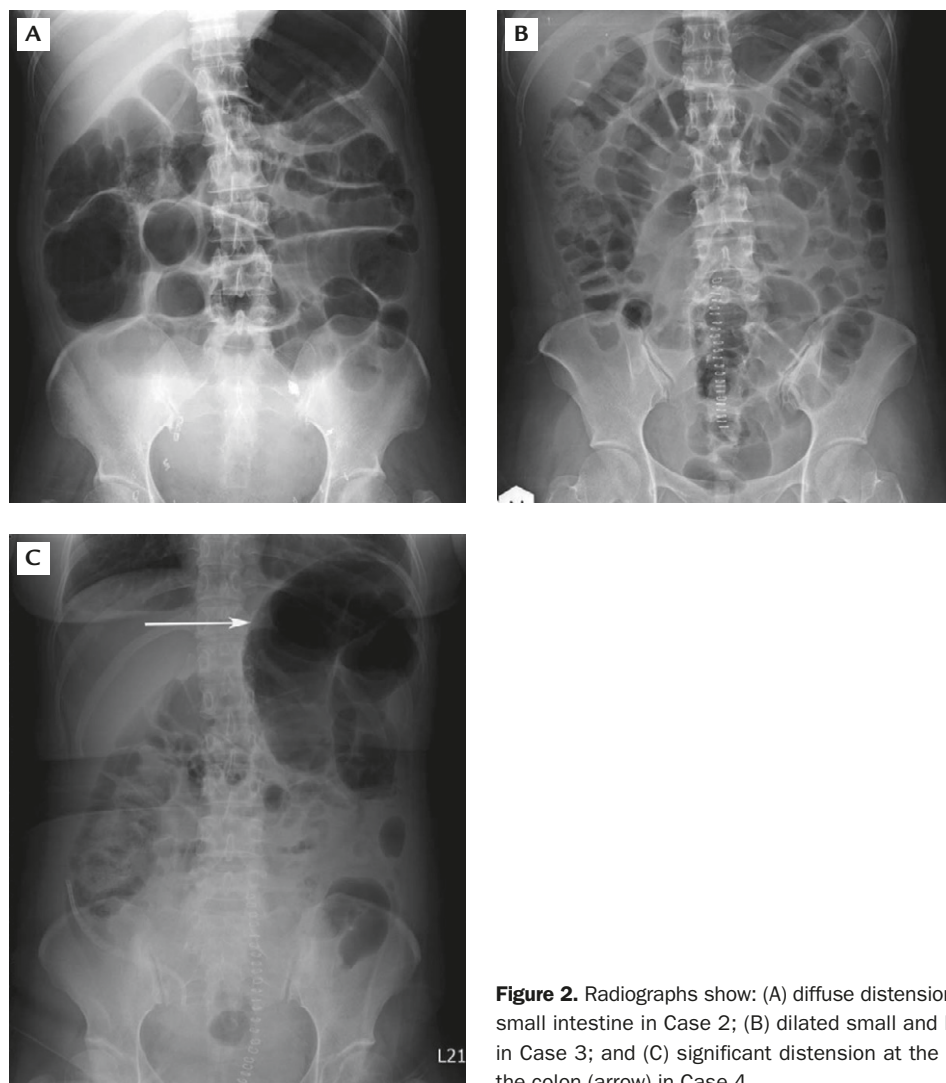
Radiographs show: (A) diffuse distension of the colon and small intestine in Case 2; (B) dilated small and large bowel loops in Case 3; and (C) significant distension at the splenic flexure of the colon (arrow) in Case 4.
